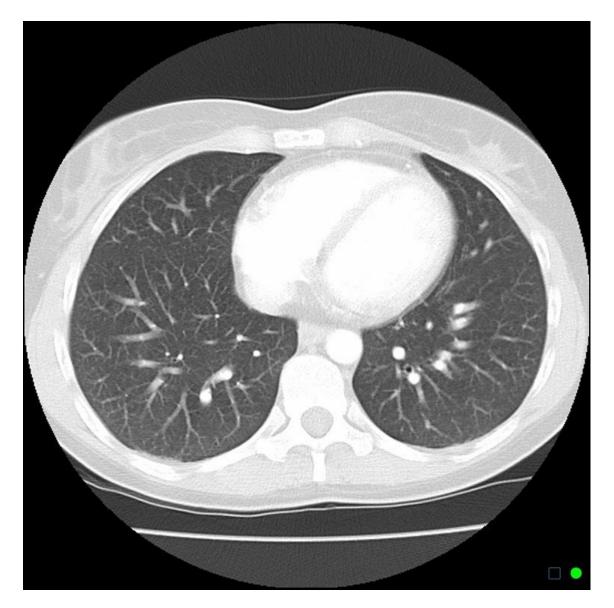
Normal chest on CT (lung window) in a 35-year-old female [140].
